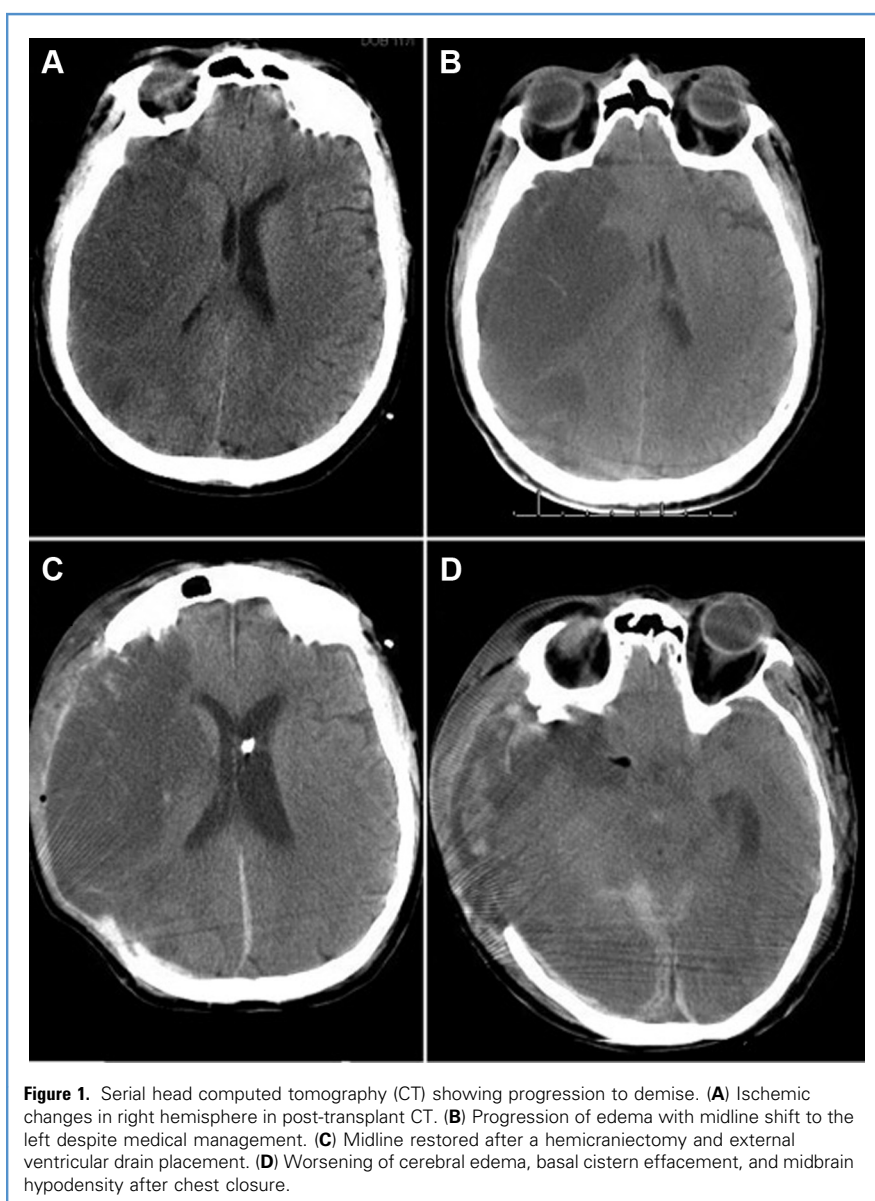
Serial head computed tomography (CT) showing progression to demise. (A) Ischemic changes in right hemisphere in post-transplant CT. (B) Progression of edema with midline shift to the left despite medical management. (C) Midline restored after a hemicraniectomy and external ventricular drain placement. (D) Worsening of cerebral edema, basal cistern effacement, and midbrain hypodensity after chest closure.
